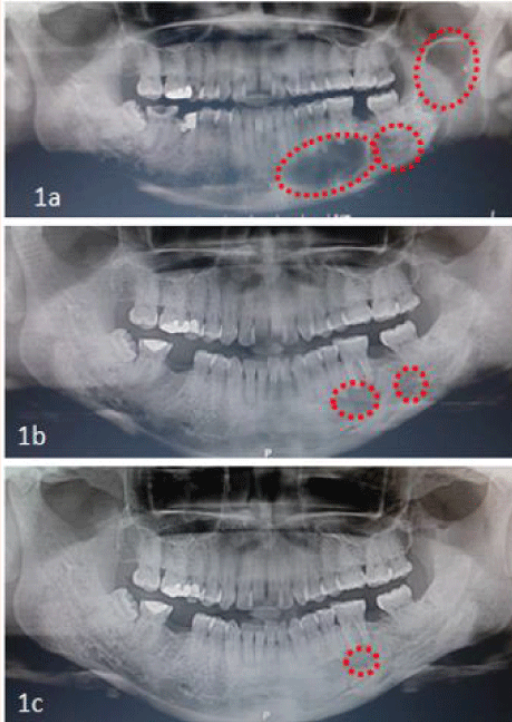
a) An orthopantomography indicated with red dotting is observed: three radiopaque areas corresponding to odontogenic keratocysts on the left branch and mandibular body, b) Control orthopantomography, seven months after the placement of a silicone decompressive valve, with reduction of mandibular keratocysts and c) The reduction of keratocyst at seven months of control is observed in red and the removal of a silicone decompressive valve is decided.
